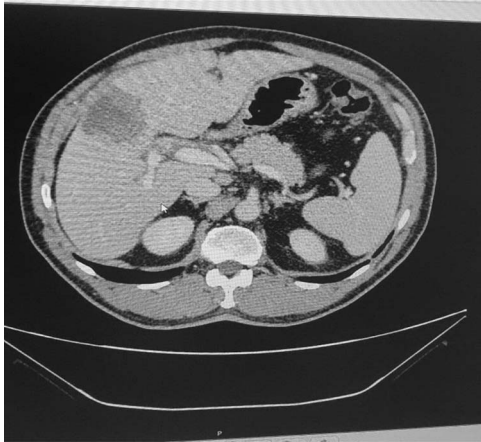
Abdominal CT scan (venous phase) with tumorous alteration of S5/S8 liver segments and infiltration of the anterior branch of the right portal vein.
